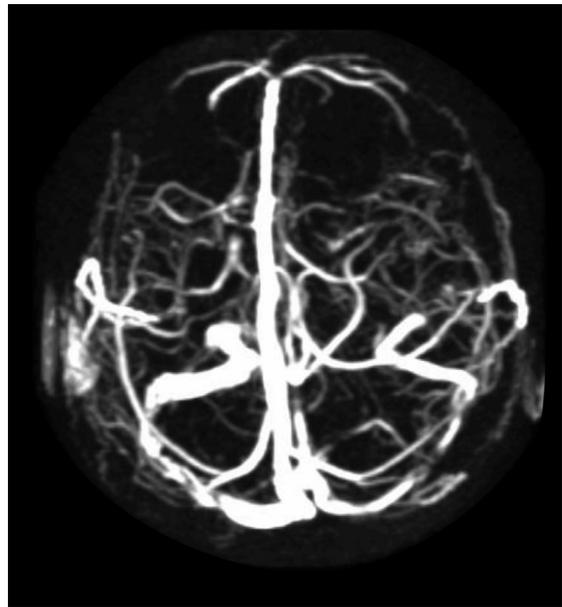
Appearance of locally decreases in calibration in bilateral transverse sinuses in magnetic resonance imaging venography
